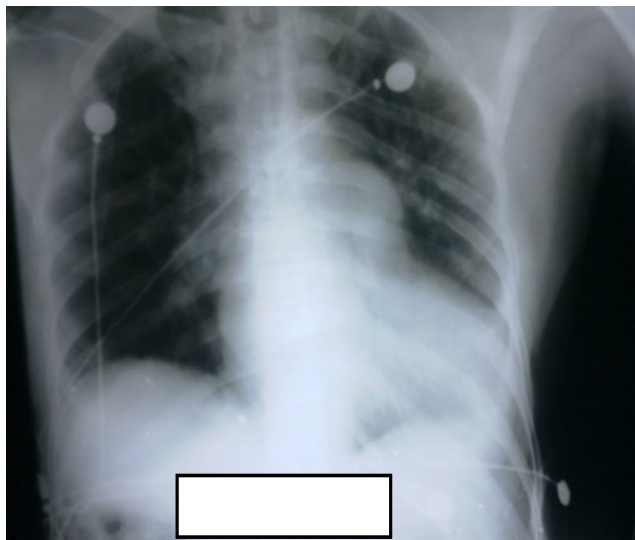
Chest radiograph showing cardiomegaly and prominence of pulmonary arteries.
